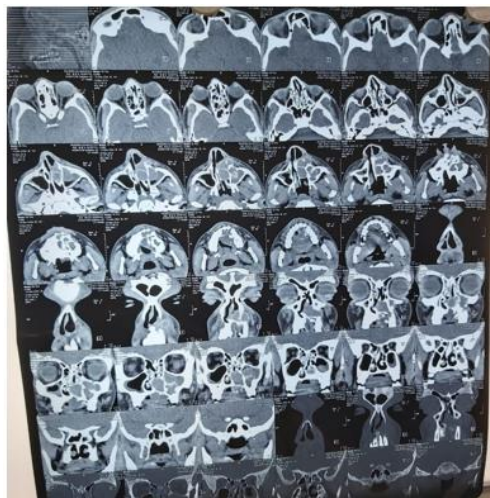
CT Scan of the paranasal sinus revealing cystic, lytic lesion the left upper alveolus
